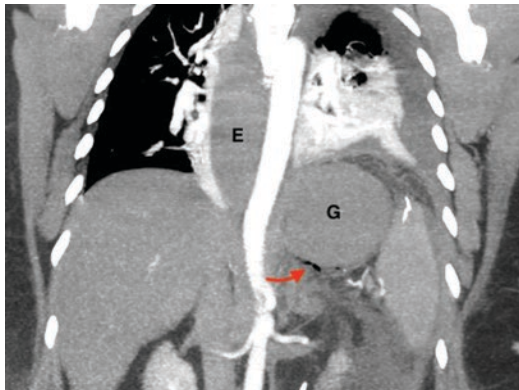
Coronal CT image post RYGB demonstrating anastomotic leak
